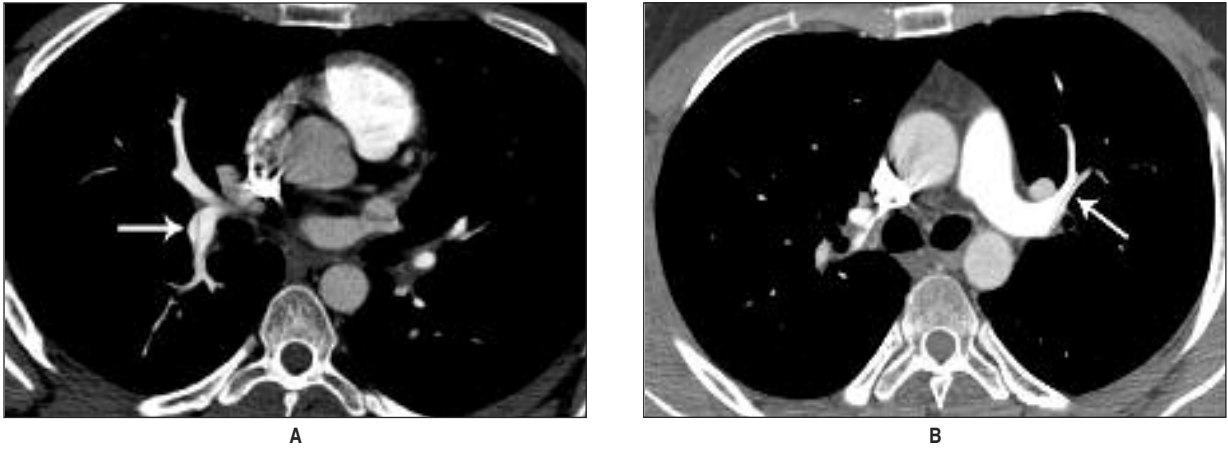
Axial multidetector computed tomographic pulmonary angiography images (A, B) show intimal flaps (arrows) in the right lower lobe and the left upper lobe pulmonary artery branches.
